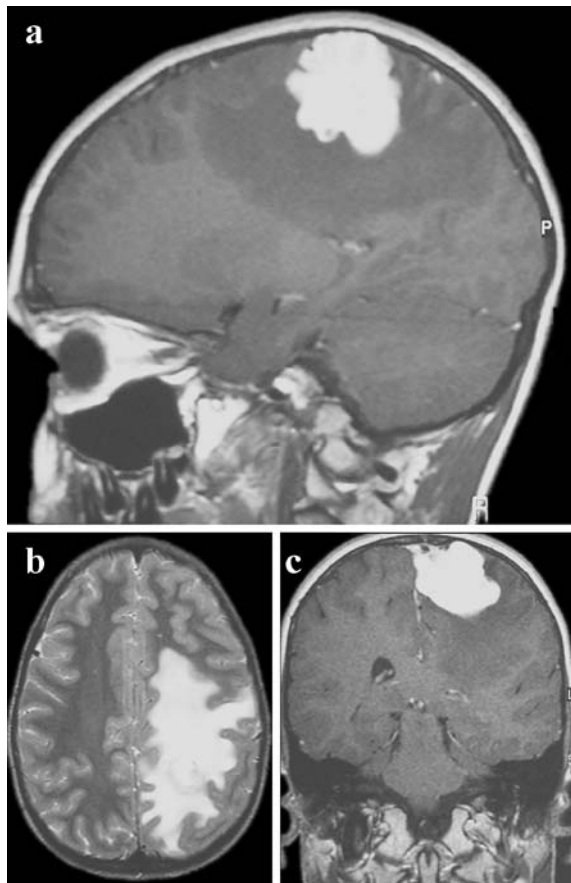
a Sagittal T1-weighted image with gadolinium showing a homogenous enhancing lesion, with important perilesional oedema. b Axial T2-weighted image demonstrating the importance of the perilesional oedema. c Coronal T1-weighted image with gadolinium, where the convexity dural attachment can be noted
